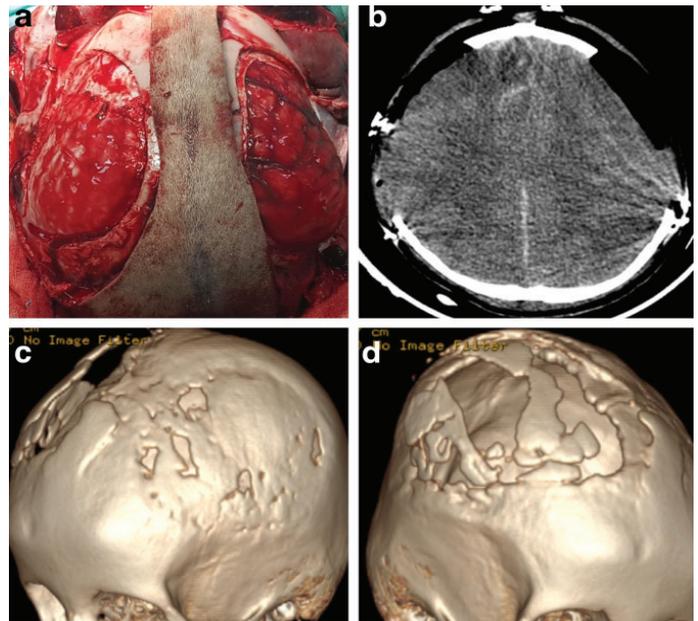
a) Perioperative image of a patient taken during bilateral decompressive craniectomy for traumatic subarachnoid hemorrhage, edema and contusion. b) Postoperative CT image of the same patient revealing effective bony decompression. c) Three-dimensional CT image of the same patient, taken 1-year postoperatively, reveals almost total spontaneous closure of the bony defect at the left side. d) Three-dimensional CT image of the same patient, taken 1-year postoperatively, reveals partial spontaneous closure of the bony defect at the right side. Cranioplasty was not needed in this patient, and she is still under close follow-up
